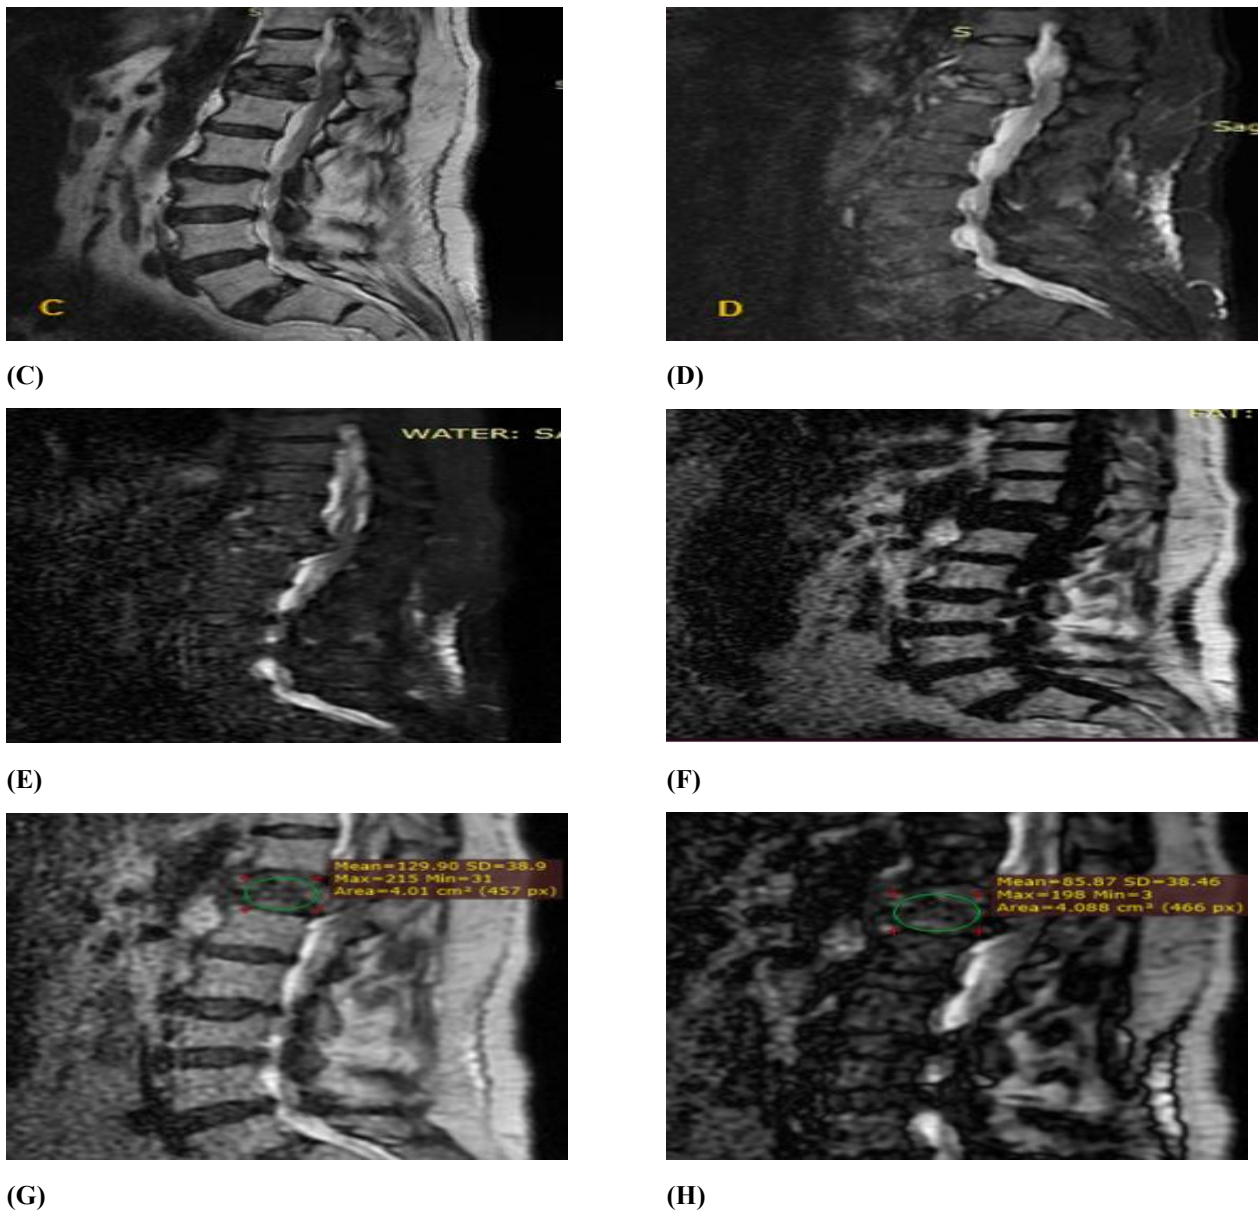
Conventional MRI (A) Sagittal T1WI, (B) Axial T1WI, (C) Sagittal T2WI, (D) Short tau inversion recovery image of the lumbosacral spine, Dixon MRI MRI of the lumbosacral spine (E) Water only, (F) Fat only, (G) in-phase image and (H) Out-of-phase image
